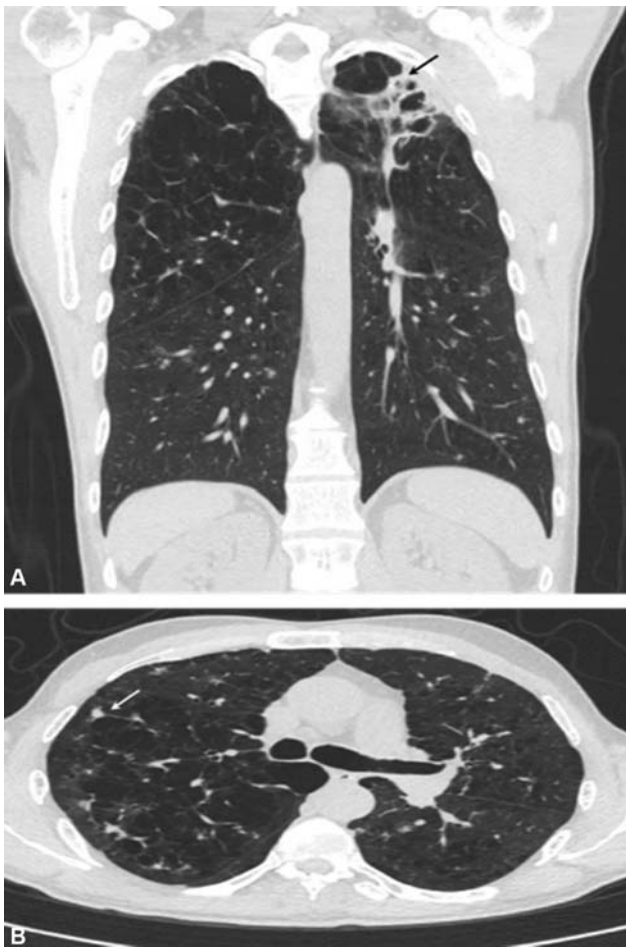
High-resolution computed tomographic scan of a man with severe emphysema, bronchiectasis, and fibrocavitary *M. xenopi* pulmonary disease. There is a large left upper lobe fibrocavitary lesion (black arrow) seen on the coronal film (A). Spiculated subcentimeter nodules (white arrow) are seen in the right upper lobe seen on axial film (B).
